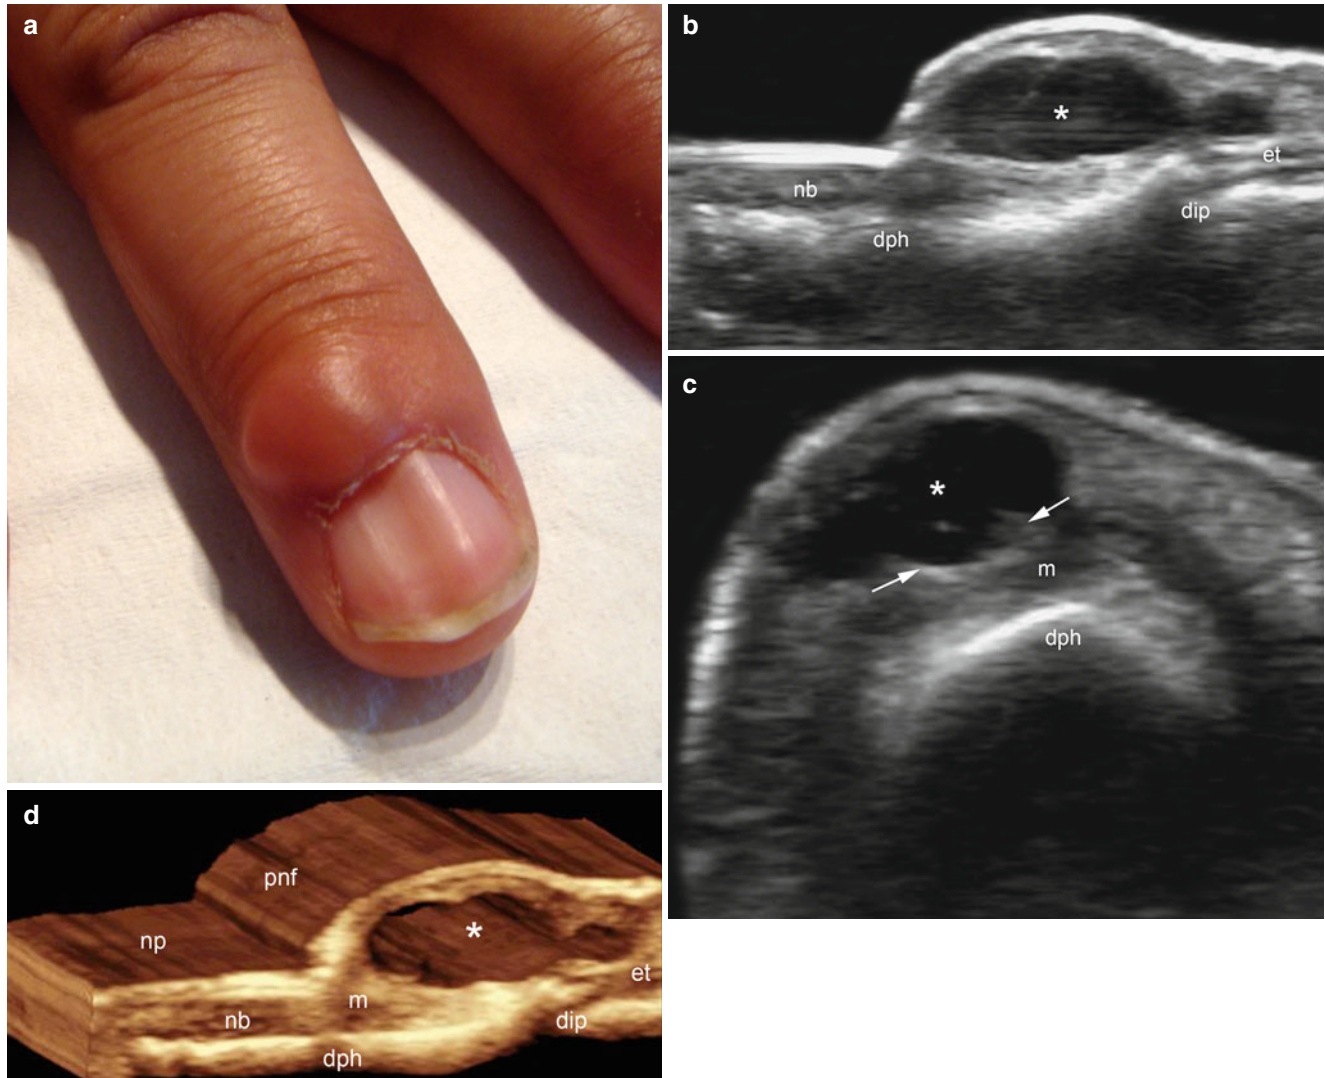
(a–d) Periungual synovial cyst. (a) Clinical image shows periungual swelling in the proximal nail fold and dystrophic changes with concavity of the nail plate. (b) Grey scale ultrasound image (longitudinal view) demonstrates a well-defined, oval-shaped anechoic cystic structure in the subcutaneous tissue of the proximal nail fold.
